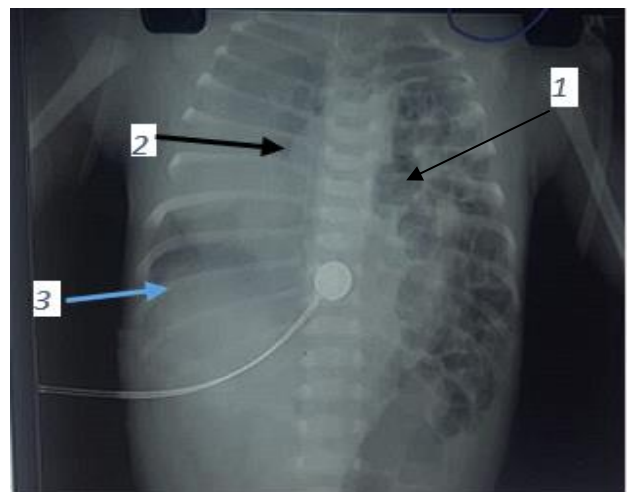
Chest X-ray of the neonate with CDH, 1) showing bowel loops in the left side of the thoracic cavity; 2) deviation of mediastinum towards the right side; and 3) right costo-phrenic angle.
